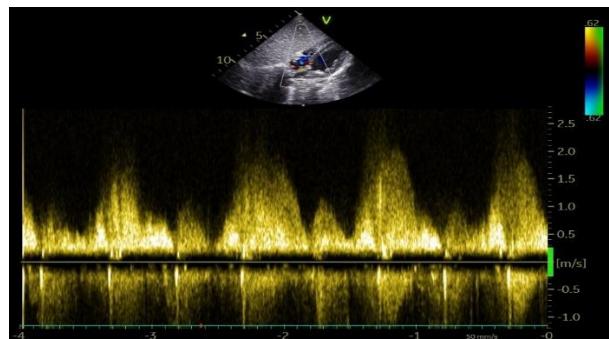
Doppler echocardiography demonstrating significant flow acceleration across the tricuspid stenosis.
